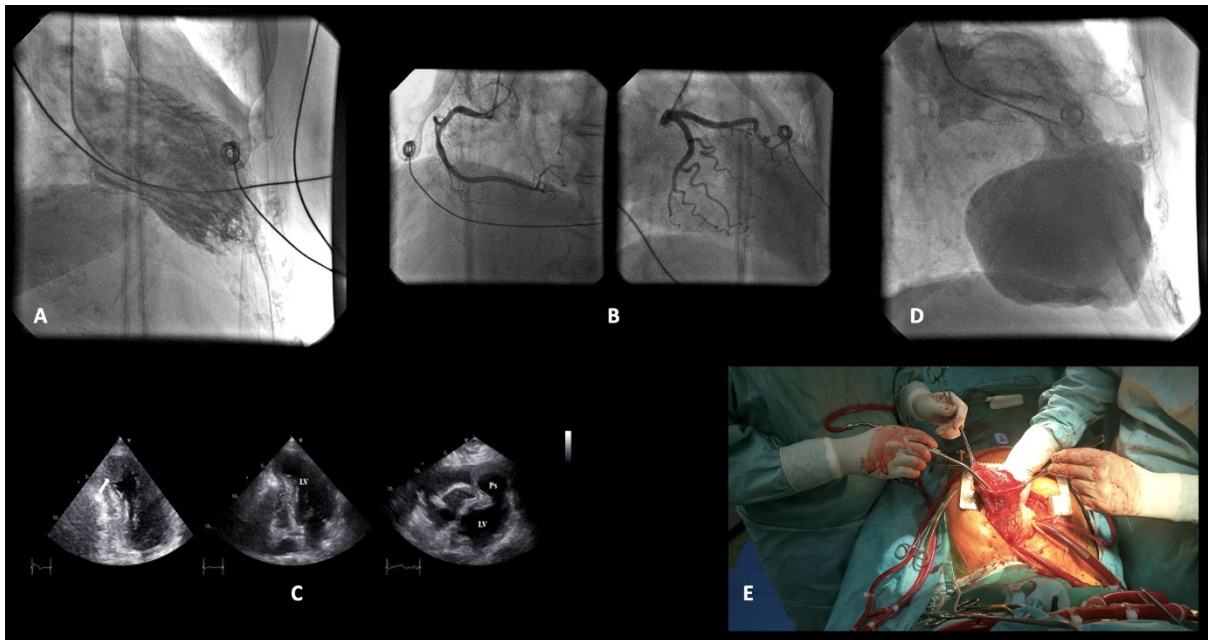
A. Left ventriculography performed at the first hospital admission showed apical ballooning with basal hypercontractility consistent with the diagnosis of Takotsubo syndrome as well as the presence of contrast filling defect in inferoapical region suspicious for thrombus formation. B. Coronary angiography performed at the first hospital admission showed normal coronary anatomy without obstructive atherosclerotic disease. C. Images from transthoracic echocardiographic examination (TTE) performed at first hospital admission showing a left ventricular (LV) thrombus (22×28 mm, white arrow) at the far left image followed by the complete dissolution of thrombus 8 weeks later later at the follow-up TTE (middle image) and huge oval non-contractile structure connected to LV *via* narrow neck surrounded by the isoechogenic wall up to 17 mm of thickness visualized at the second hospitalization. D. Left ventriculography performed at the second hospitalization revealing an inferoapical pseudoaneurysm structure 72×65 mm in size with the neck diameter measuring approximately 21 mm. E. Surgical resection of the pseudoaneurysm (aneurysmectomy) and closure of the LV by the double-layered pericardial patch was performed by the cardiac surgeons
